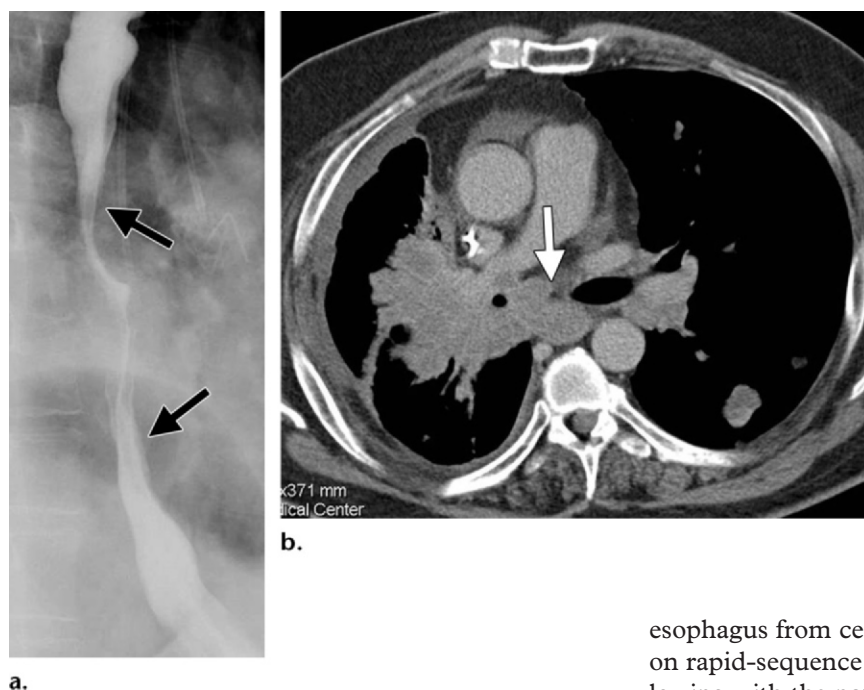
Lung cancer involving the esophagus. (a) Single-contrast LPO image shows mass effect throughout the midthoracic esophagus (arrows). (b) Contrast-enhanced CT image shows a large lung cancer invading the mediastinum, with severe compression of the esophagus at this level (arrow).
